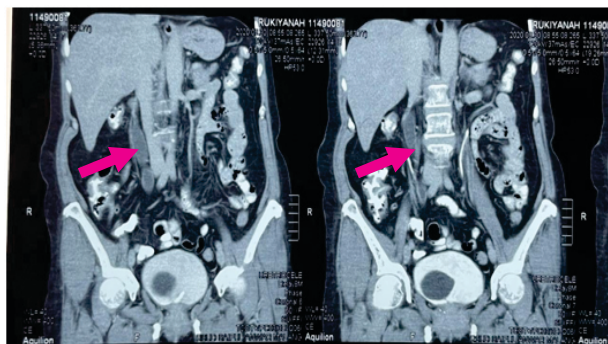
Abdominal CT Scan with Contrast. Duplex collecting system with right upper severe hydroureteronephrosis (red arrow) with intravesica ureterocele (purple arrow).
